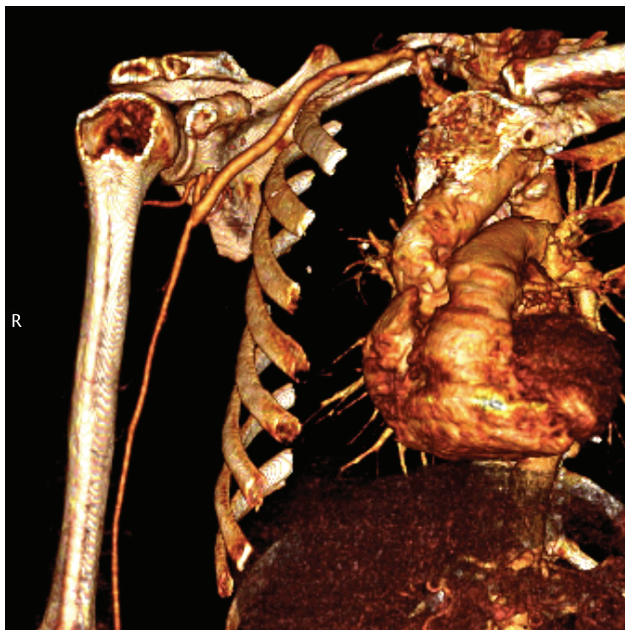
CT angiogram and three-dimensional reconstruction obtained after placement of arterial graft and PTFE prosthesis.
